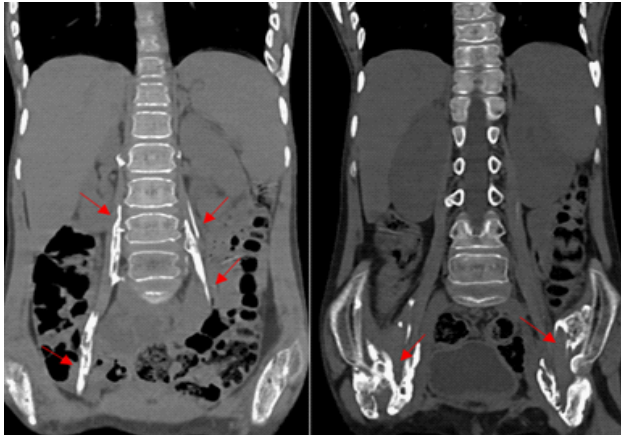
(a and b) CT (bone window) paravertebral region in coronal view shows a bizarre-shaped thick osseous band extending along the iliopsoas muscle down to its insertion onto the lesser trochanter of the femur on both sides (red arrows).
